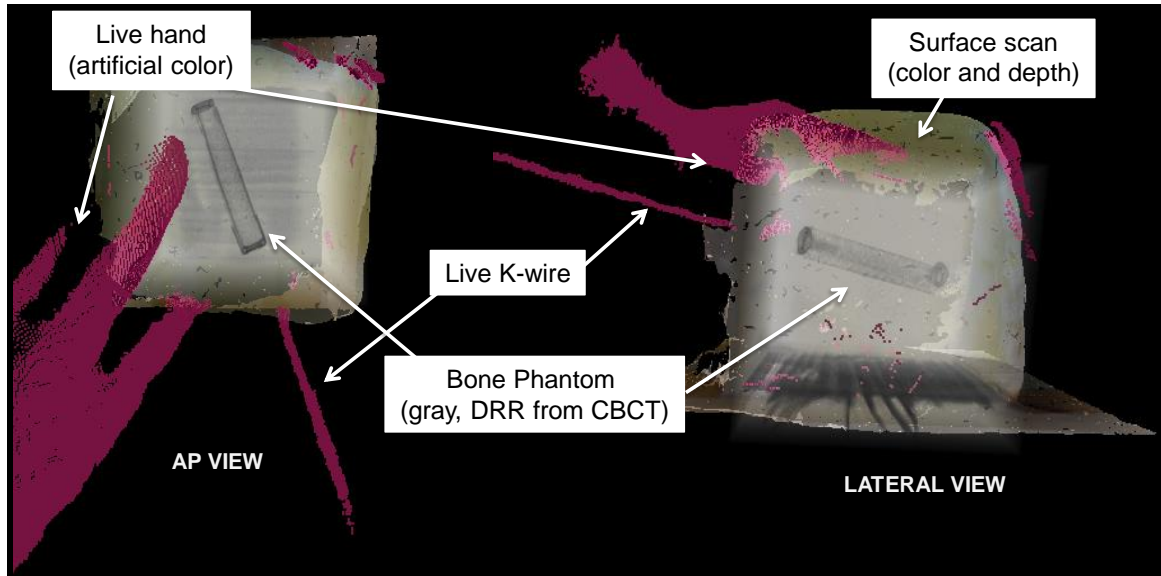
The Augmented Reality visualization provides surgeons with multiple views of entire surgical site. The scene includes live representations of the hand and surgical tools (e.g. K-wire) as artificially colored point clouds, the colored surface scan of the patient, and dynamically adjusted DRR from the CBCT scan. This allows the surgeon to dynamically change the view during the procedures.
